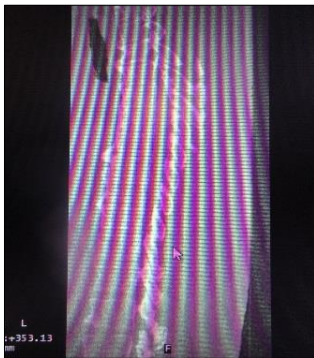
Sagittal dorsal CT scan – Bone window
